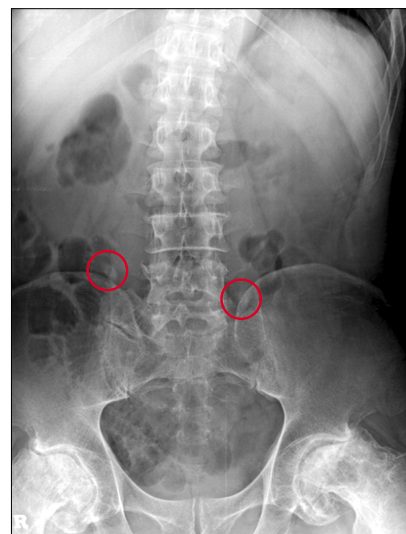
Plain abdominal radiograph showing an 18.1 mm stone in the right ureter, an 18.5 mm stone in the left ureter, and ankylosis of the bilateral hip joints (see each stone inside the circles).
